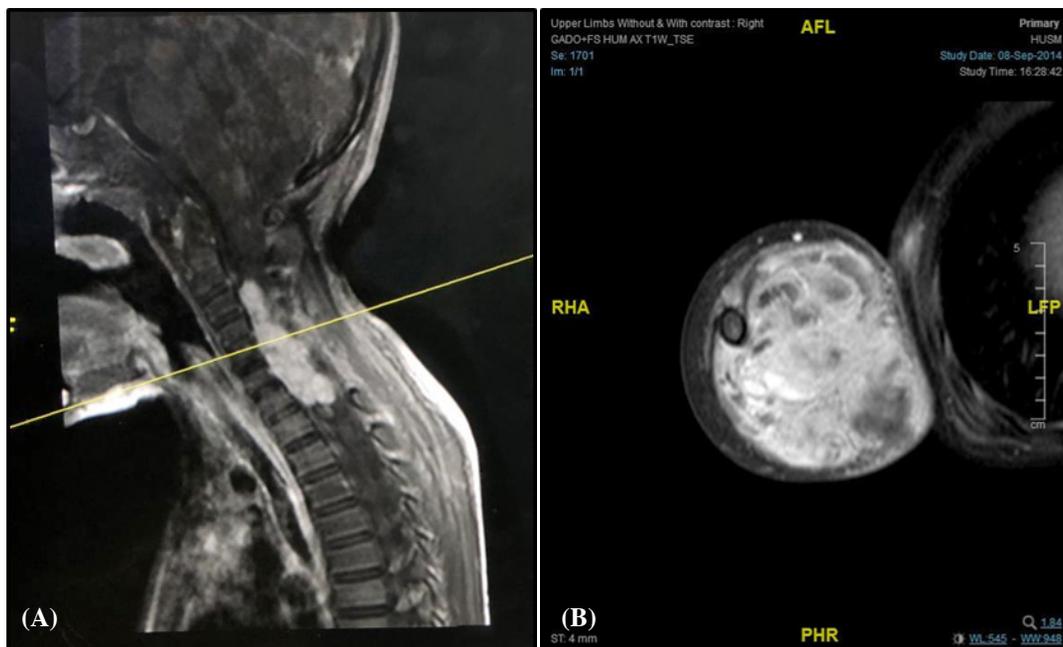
(A) MRI show intradural extramedullary mass at the right cervical region from the level of C4 to the C8, which appear cystic, heterogeneously hypointense on T1 and hyperintense on T2 and features suggestive of benign peripheral nerve sheath tumour. (B) MRI shows a large intermuscular capsulated mass at the right medial side of the proximal arm, causing splaying and compression of the surrounding muscle, and this lesion appears solid with cystic component and reported as malignant Schwannoma.
